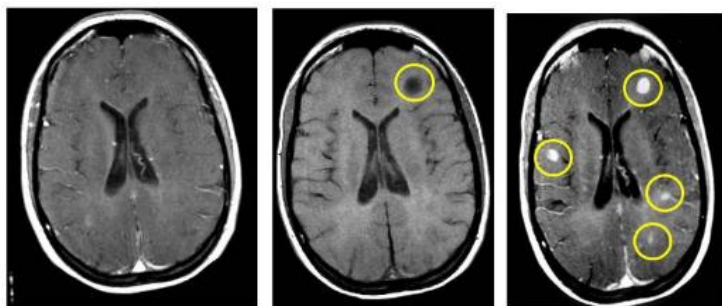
T1-weighted MRI with lesions [43]
